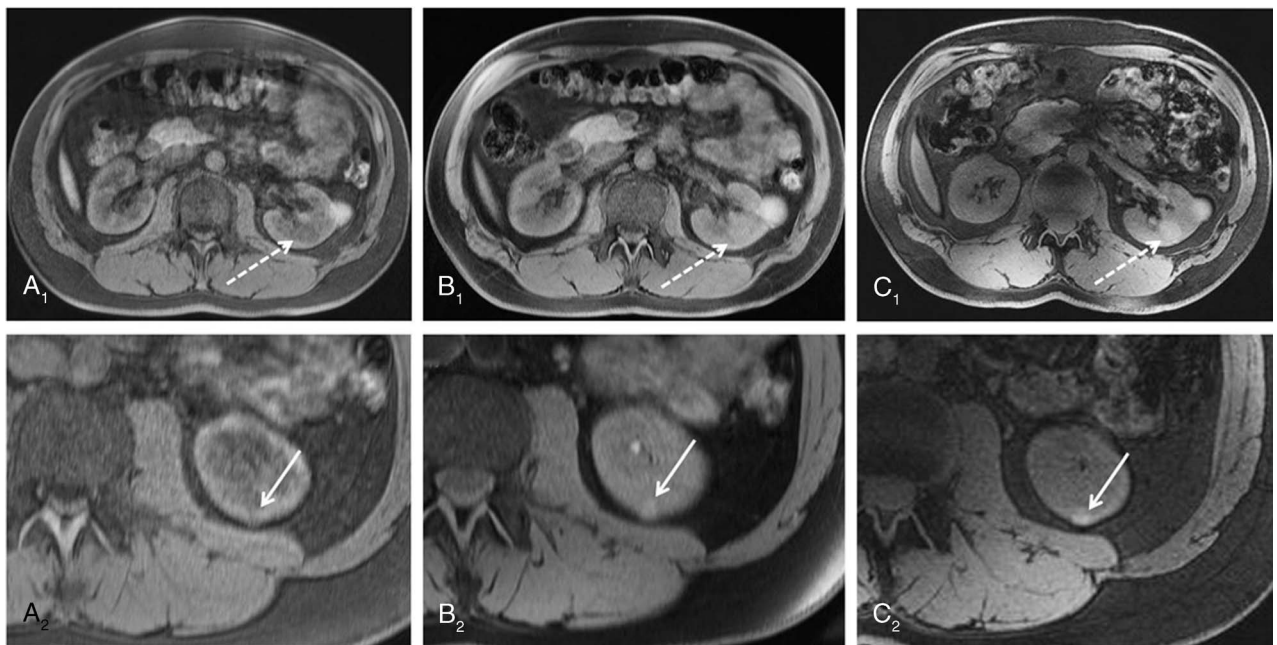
Three-dimensional VIBE MRI at 1.5 T (A), 3 T (B), and 7 T (C) in the same subject. Seven Tesla 3D VIBE MRI demonstrated diagnostic potential by means of pathology detection, as it revealed a second hemorrhaged renal cyst (dashed arrow C_1) not displayed at lower field strengths. In the second row, arrows show a further very small renal cyst in the same subject, which is also best visible at 7 T (C_2). Reproduced with permission, open access, Laader et al.¹¹⁷
